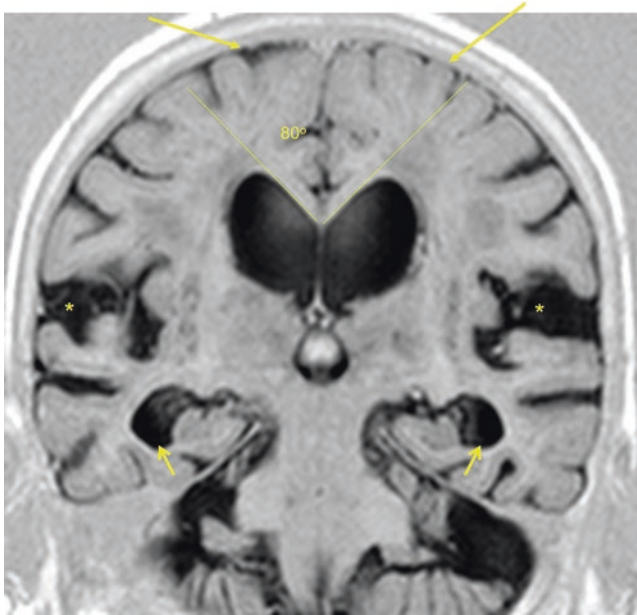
73-year-old man with a diagnosis of idiopathic normal pressure hydrocephalus. All components of DESH are clearly visible on this coronal T1-weighted image. Ventriculomegaly (Evans index >0.3); high-convexity tightness (arrows); enlarged Sylvian fissures (asterisks); reduced callosal angle; and marked dilatation of both temporal horns not explained by hippocampal atrophy (arrows)
